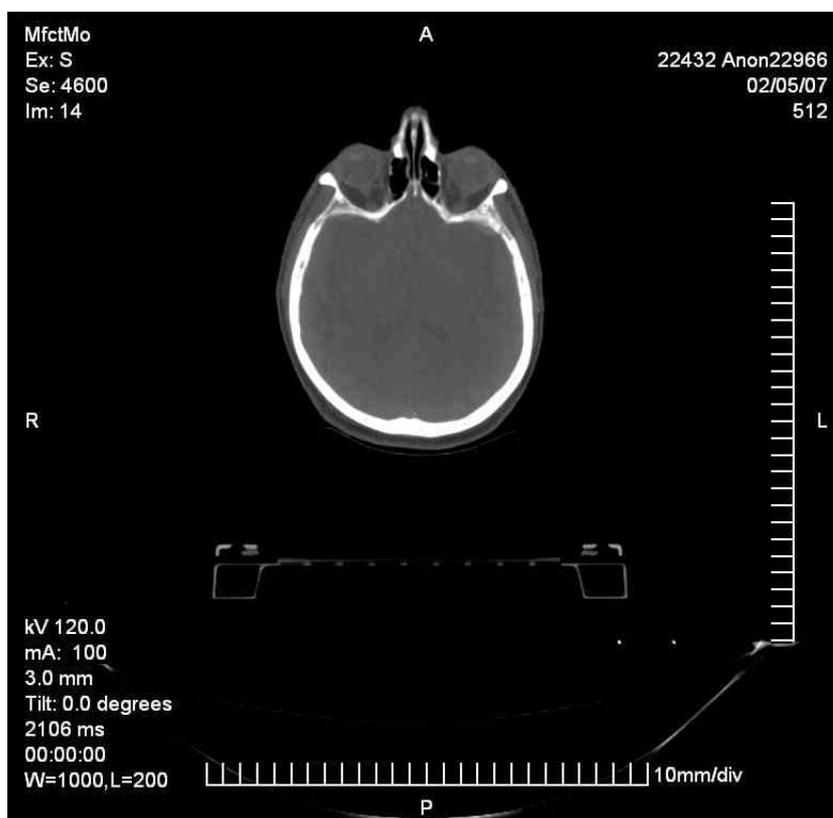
An example of an anonymised CT slice from the CT image series used in the current thesis.
